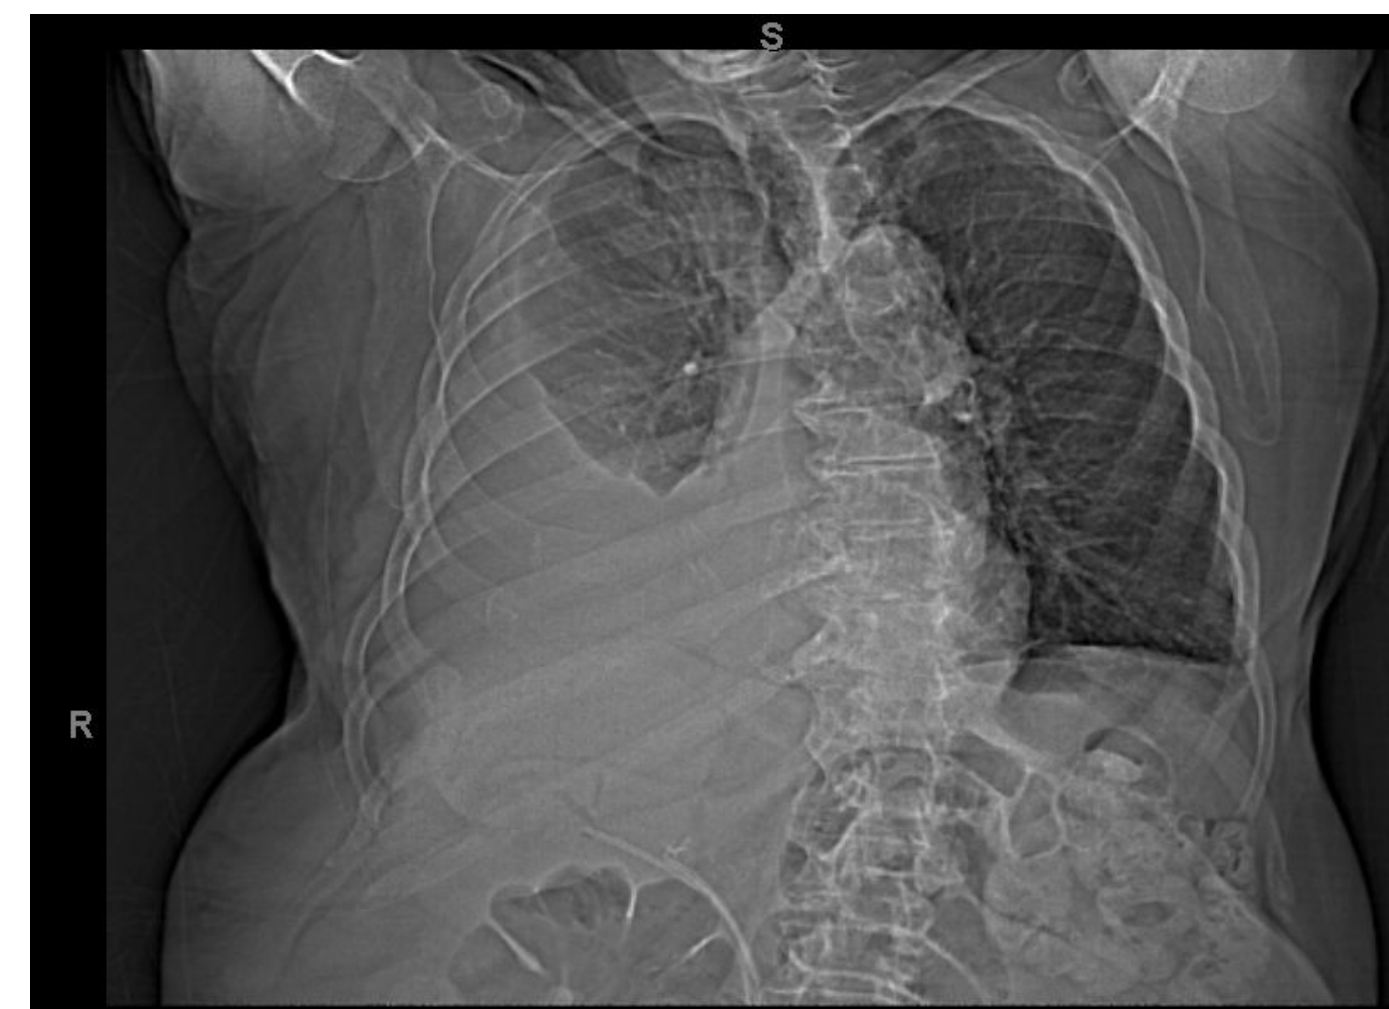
CT Chest/Abd/ Pelvis
